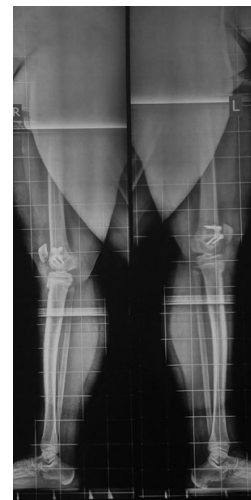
The X-plate on the left side was unintentionally inserted slightly on the anterior aspect of the physis, compared to his right side; however, the final x-ray after an 11-month follow-up showed no difference in the knee recurvatum bilaterally.
